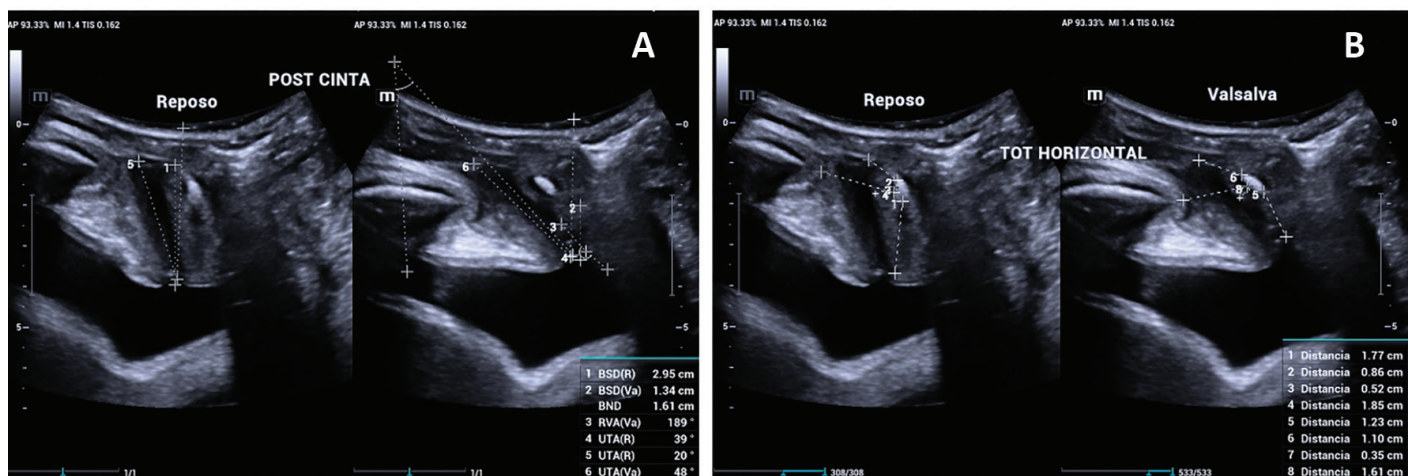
A) Transoperative ultrasonographic images of urethral mobility at rest and valsalva, observing immediate improvement in the descent of the bladder neck in Valsalva and improvement in the stability of the pubourethral ligament. B) Transoperative ultrasonographic images performed profilometry of the tape, corroborating the distance of the tape within normal parameters and ruling out post-application urethral compression
